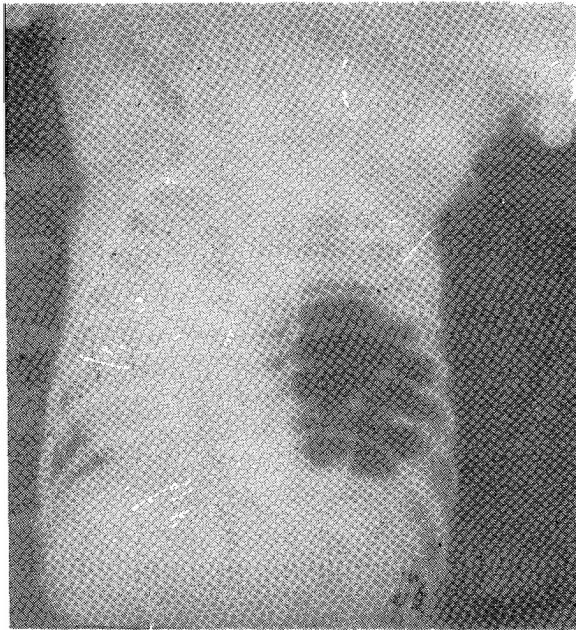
(a) Preoperative posteroanterior (PA) view of a chest radiograph showing a left sided congenital diaphragmatic hernia (CDH) as a large tubular lucency in most of the left hemithorax.
